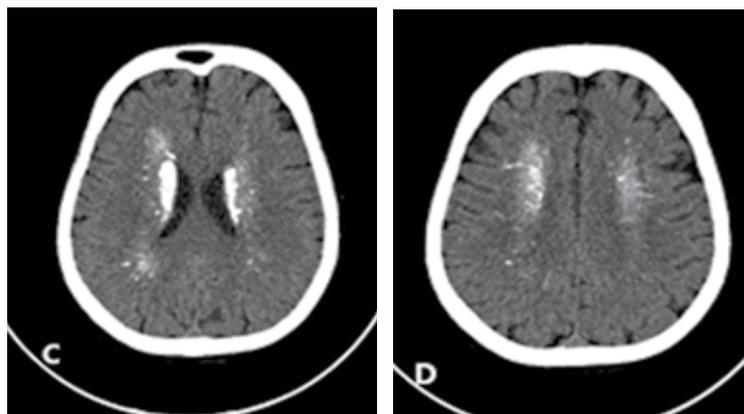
Non-contrast computed tomography
